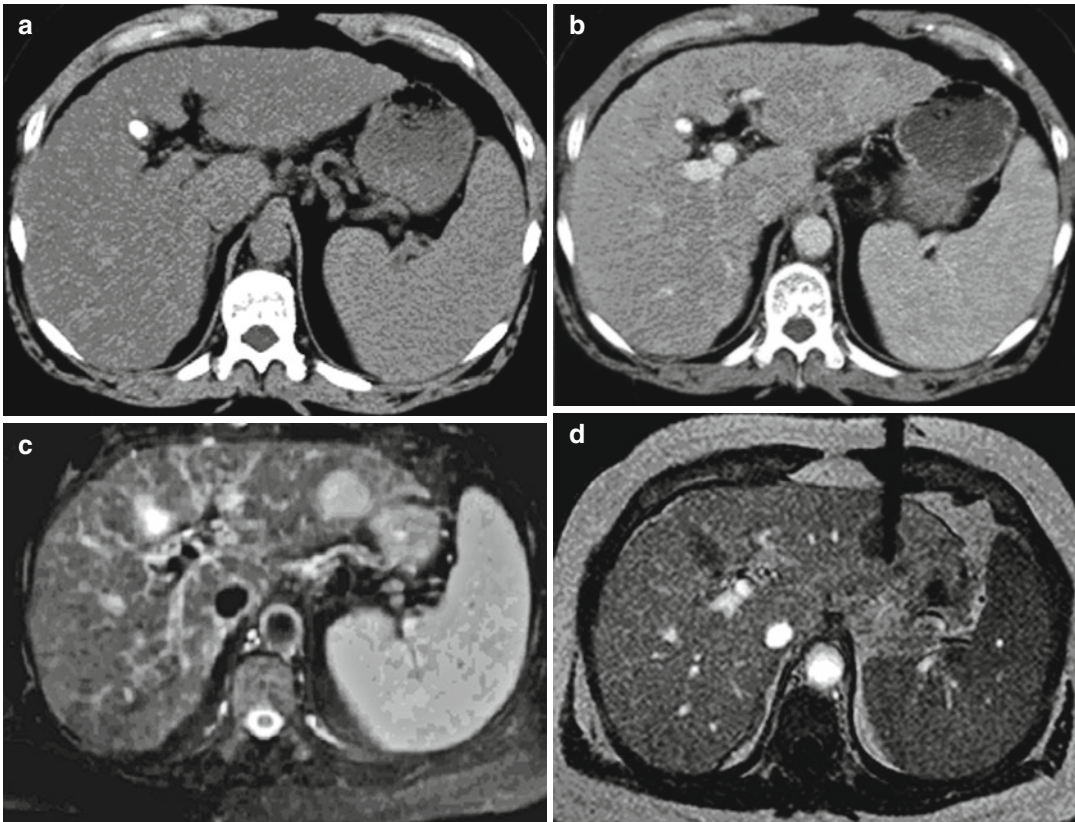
A liver tumor was initially overlooked on the CT images (a, b). It is clearly visualized on the T2-weighted imaged (c) and was biopsied using a T1-weighted
